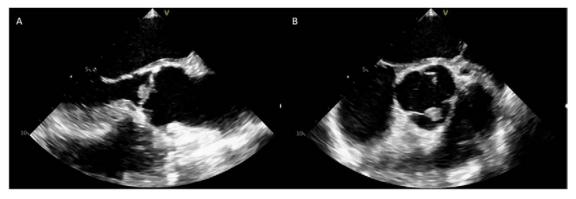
Trans-oesophageal echocardiographic (TOE) image of papillary fibroelastoma on the aortic valve in long axis (A) and short axis (B) Courtesy Chahin et al.²²
